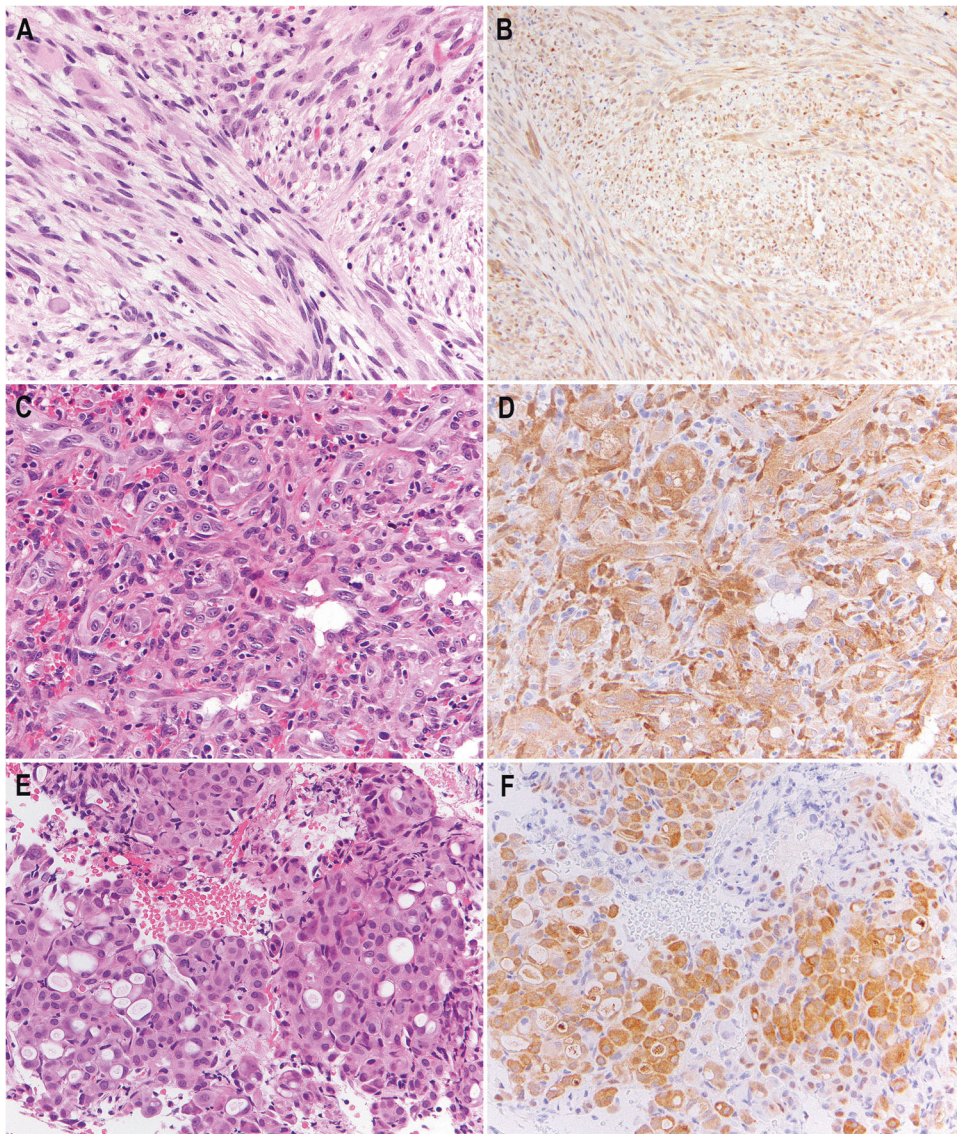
YAP1-CT in other epithelioid vascular neoplasms. A Pseudomyogenic hemangioendothelioma, comprising intersecting fascicles of myoid spindle cells with eosinophilic cytoplasm. B There is retained expression of YAP1-CT. C Epithelioid hemangioma composed of blood vessels lined by epithelioid tumor cells and admixed eosinophils. D Retained cytoplasmic expression of YAP1-CT. E Epithelioid angiosarcoma, consisting of sheets of tumor cells with cytoplasmic vacuoles. F There is cytoplasmic positivity for YAP1-CT.
